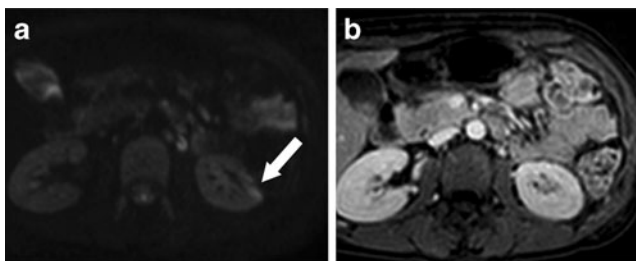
False-positive DWI study. a On axial DWI SENSE with $b=700\text{ s/mm}^2$ there was a small parenchymal area of restricted diffusion, without enhancement after administration of contrast medium in the T1-WAVE sequence (b)
